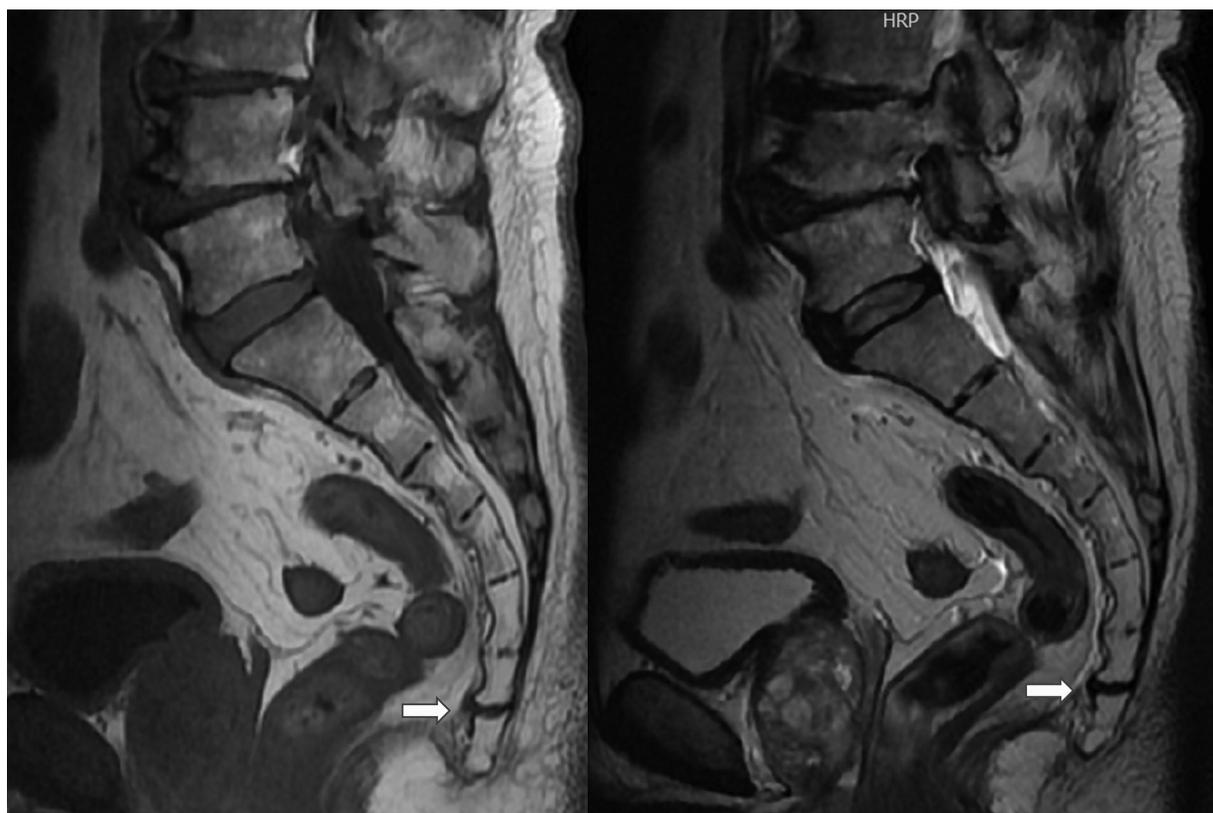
The magnetic resonance imaging in sagittal plane, revealing coccygeal disc disease.
